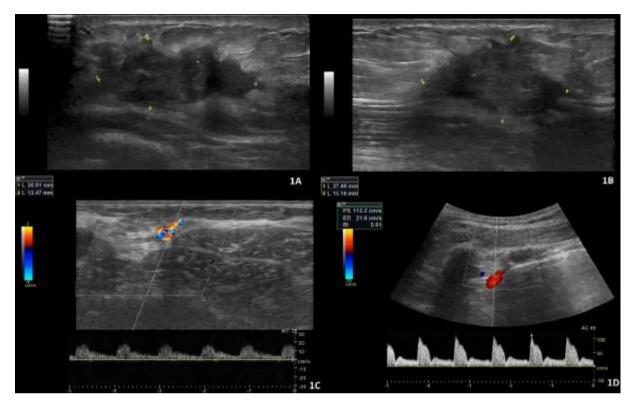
1A-1B An irregular shaped solid mass lesion in the upper outer quadrant of the right breast with a spicule contour, 30x27x15 mm in size, diagnosed as invasive ductal carcinoma. 1C:Evaluation of lateral thoracic artery by power doppler ultrasonography.1D: Evaluation of the internal thoracic artery by power doppler ultrasonography.
